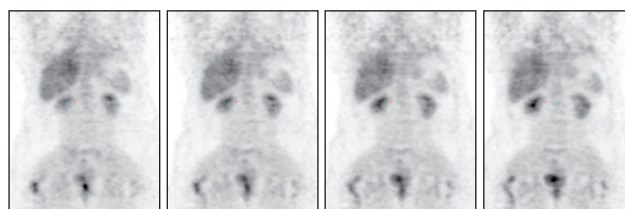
Images of <sup>18</sup>F-FDG-PET in a patient with FUO that pinpointed the cause of fever to be an infected hip, confirmed by culture. This series demonstrates the advantage of functional imaging.
